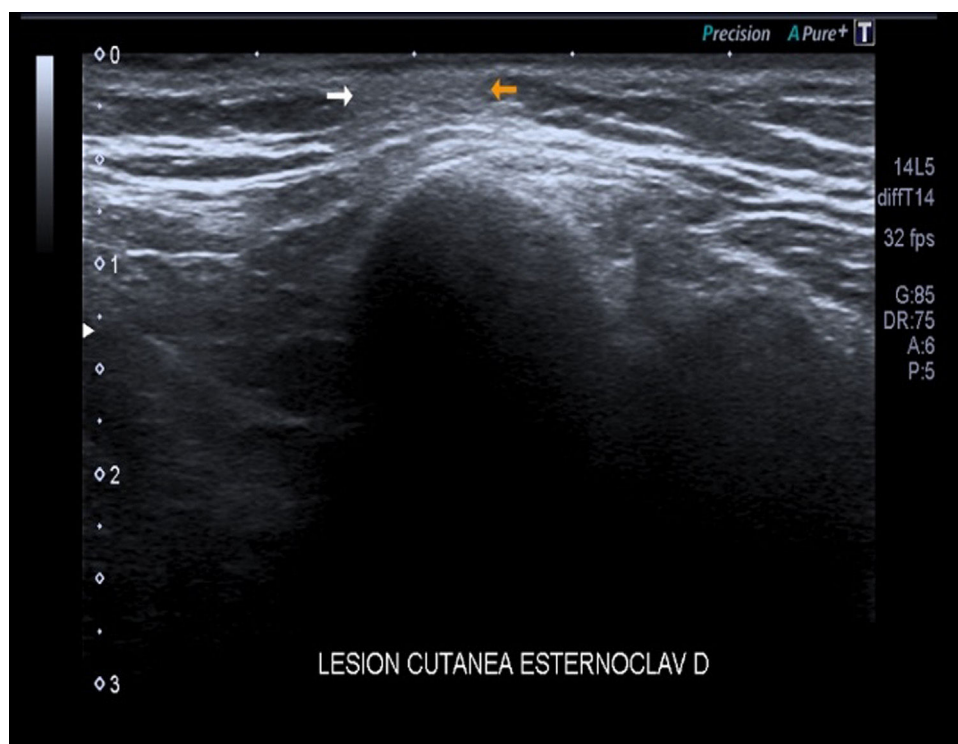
Ultrasound study with well-defined nonencapsulated, hypoechoic subcutaneous lesion.
